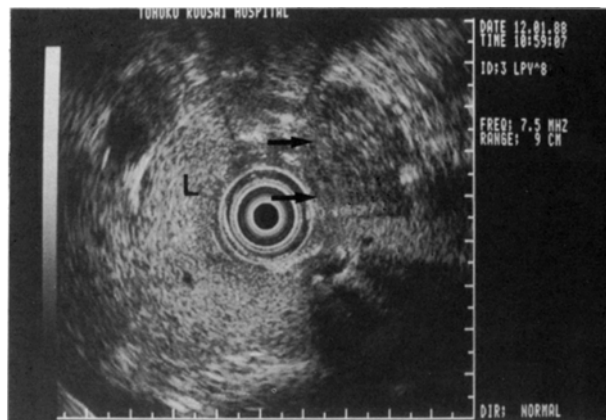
Endoscopic ultrasonography. The mass accompanied with posterior echo enhancement and lateral shadow (arrows). (L: liver)
